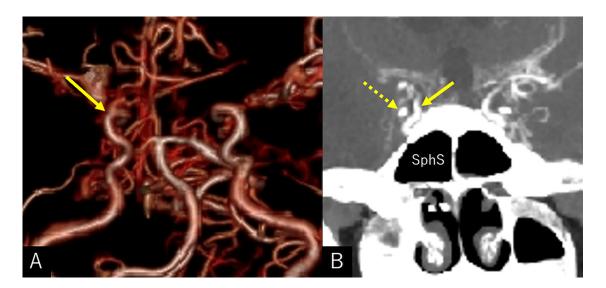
Anteroposterior view of the 3-dimensional computed tomography angiography (A) and postcontrast coronal computed tomography (B) performed at the completion of antibiotic therapy showing the paraclinoid segment of the right internal carotid artery restored to normal diameter (arrow). SphS: sphenoid sinus; dashed arrow: anterior clinoid process.
